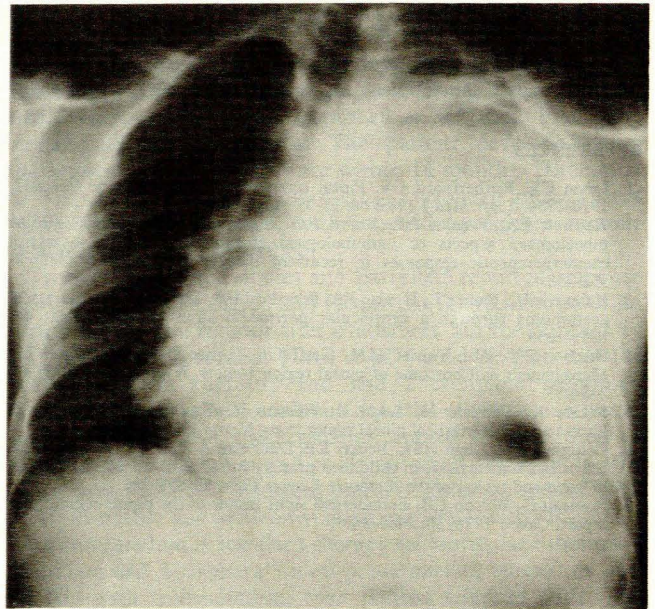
Case 1. Pre-radiography clinical diagnosis: pancreatitis or peptic ulcer. Post-radiography diagnosis: strangulated colonic hernia. Operation: strangulated gangrenous colonic hernia. The patient survived. Top: Pleural effusion opacifying whole of left hemithorax with gas-fluid collection due to hernia at left base. Bottom: Supine view shows distension proximal to distal transverse colon (C = distended transverse and ascending colon; the other bowel lucencies are all due to distended small intestine).
